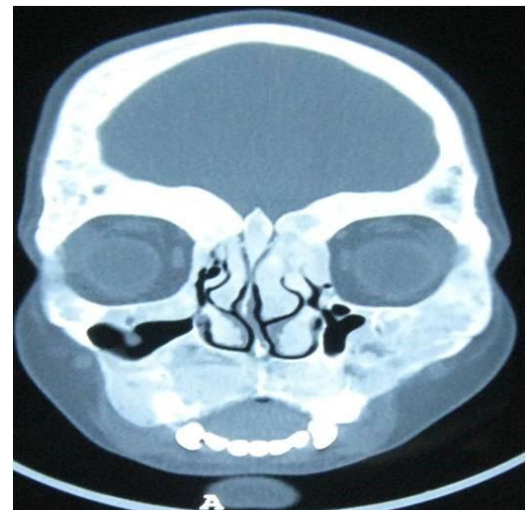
Computed tomography scan showing nasal, lacrimal, maxillary, zygomatic and inferior nasal conchae
